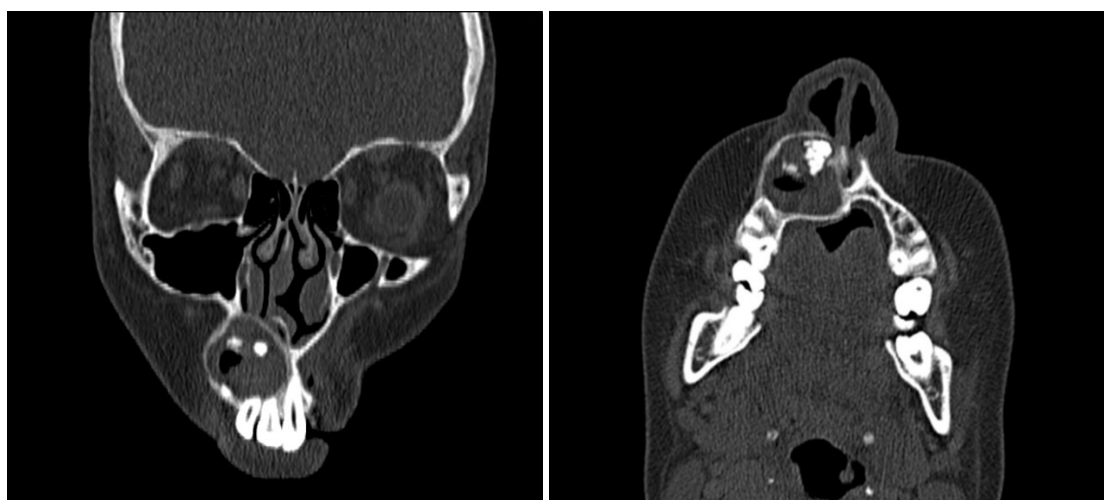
Contrast enhanced computed tomography showing unilocular expansile lesion with specks of calcification within (coronal and axial view).
